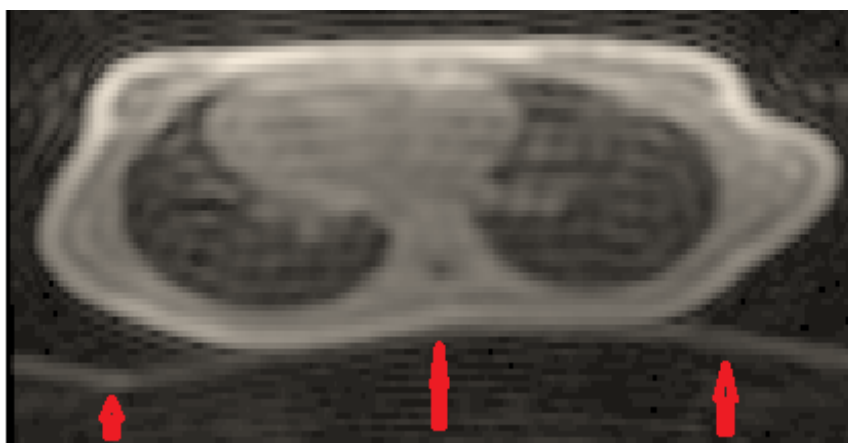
Shows an axial lung MR image which captured by protocol 2 with an artefact horizontal line as indicated by red arrows.
